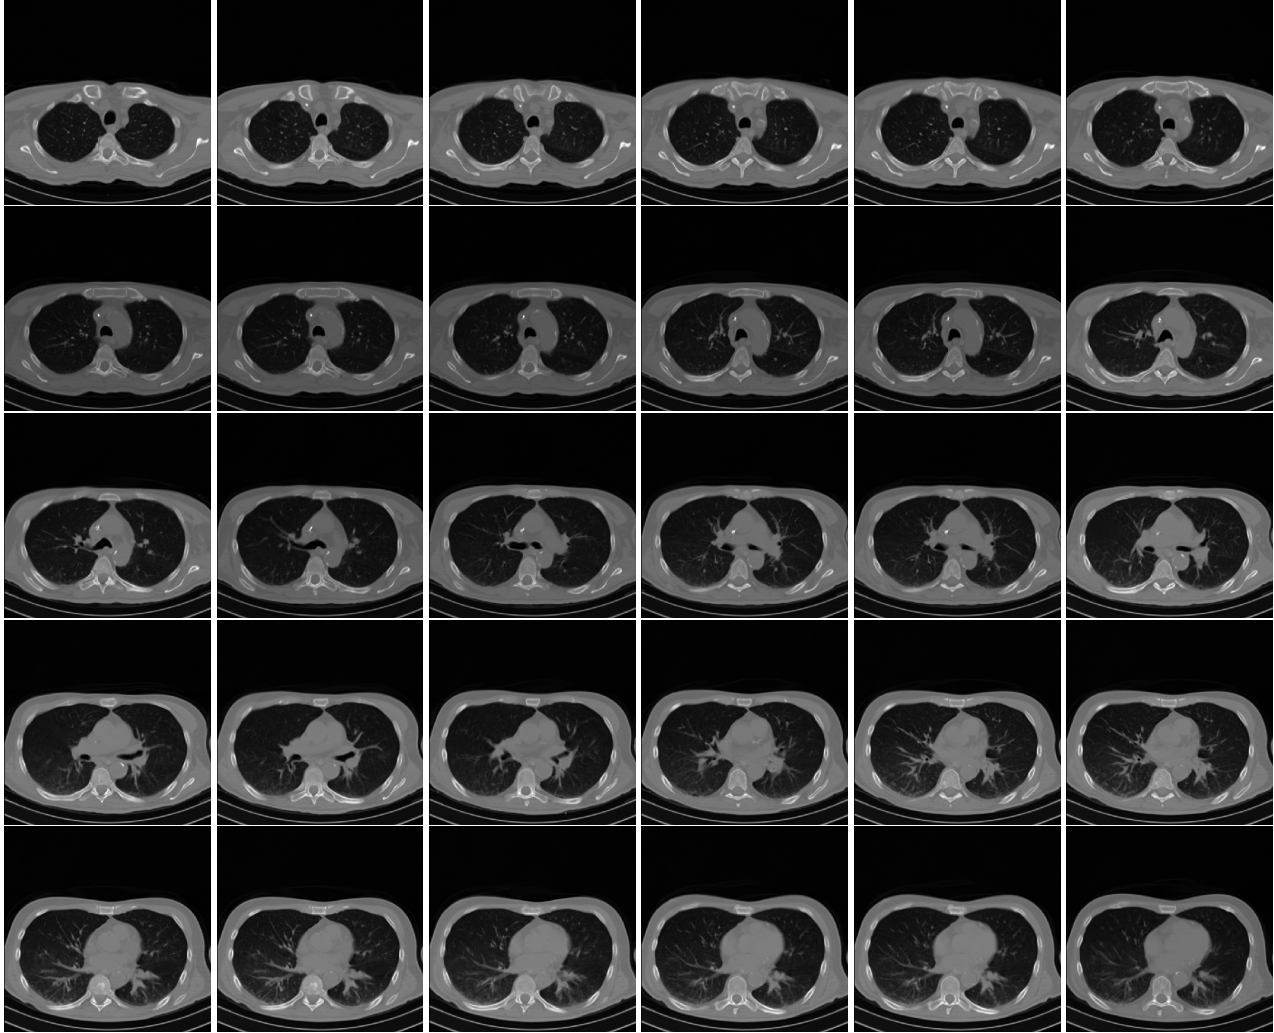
Slices from a non COVID-19 CT scan.
